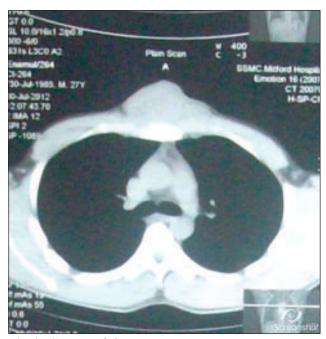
CT scan of chest
